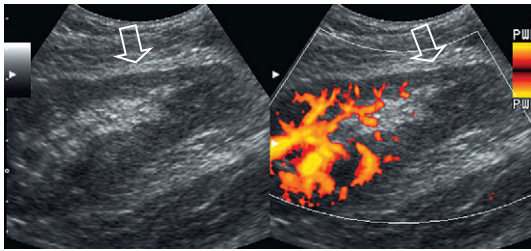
Side-by-side longitudinal grey-scale and power Doppler image of the low pole of a poorly functioning transplant kidney. Note the thin cortex (arrow) and complete absence of flow on power Doppler at the lower pole. This renal transplant required two arterial anastomoses. Thrombosis of the lower pole artery was suggested and confirmed angiographically. Additionally, ultrasound-guided biopsy of the upper pole identified acute rejection.
